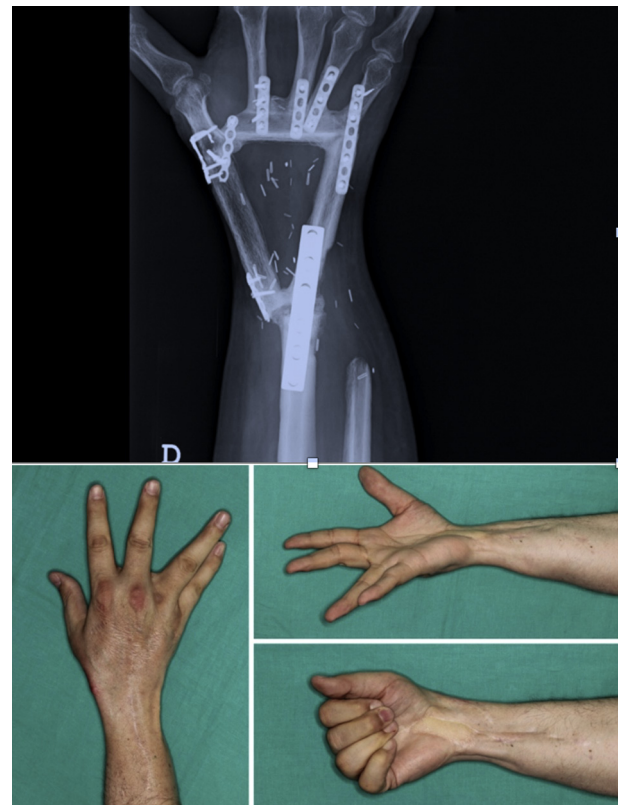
X-ray result 1 year after the procedure. Functional result at 6 years after the procedure.
